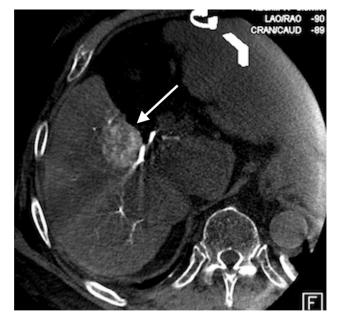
C-arm CT image after gadolinium contrast injection with the white arrow demonstrating tumor blush in the right hepatic lobe.
